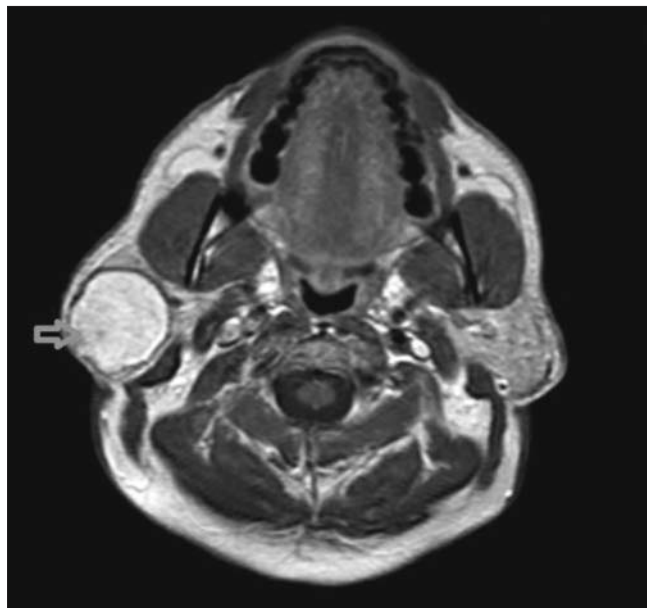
MRI image of parotid gland lipoma (arrow)
